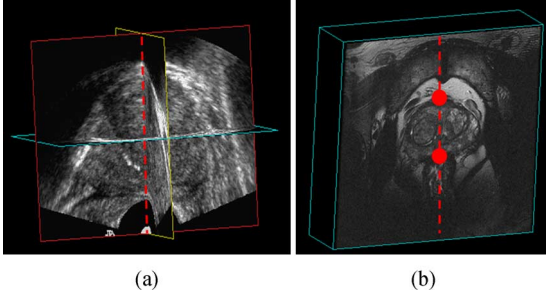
Examples of the selection of the rotational axis from transverse views in (a) TRUS and (b) MR images.
